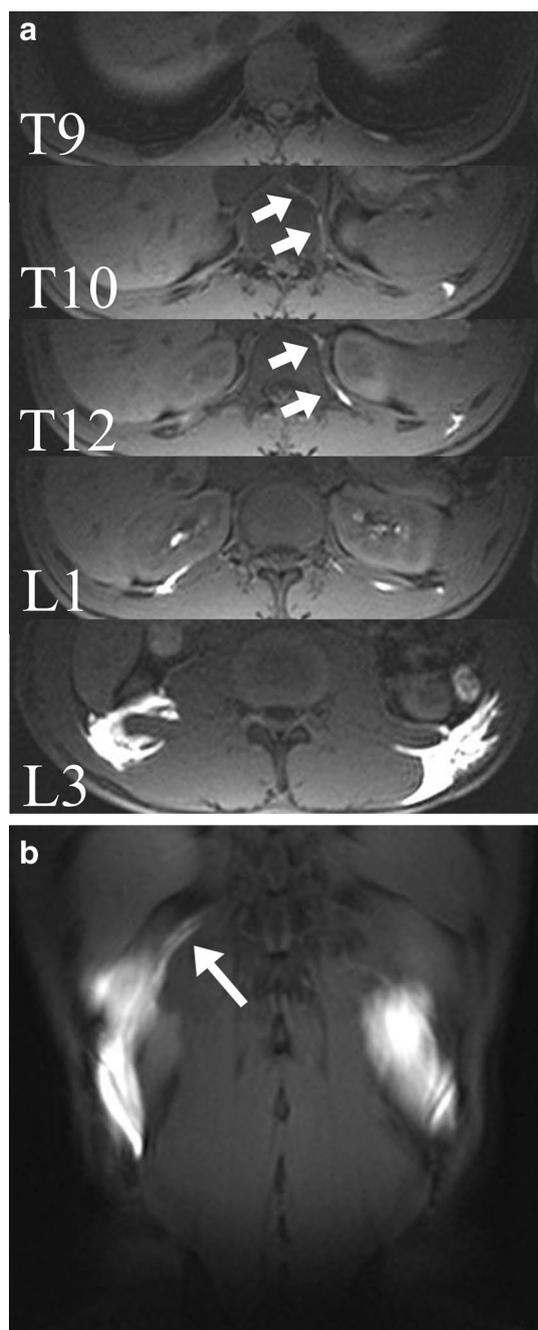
Magnetic resonance imaging (MRI) of local anesthetic (LA) spread into the paravertebral space (PVS) after QL B2 and QL Bi. a LA spread into the PVS was detected by MRI following QL B2 (white arrows). The volunteer imaged in this figure underwent left-sided QL B2 (right side of each image). In contrast, MRI did not show LA spread into the PVS following QL Bi. The volunteer in this image underwent right-sided QL Bi (left side of each image). Top image: Level of the T9 vertebral body. Second image from the top: Level of the T10 vertebral body. Third image from the top: Level of the T12 vertebral body. Second image from the bottom: Level of the L1 vertebral body. Bottom image: Level of the L3 vertebral body. All images are from the same volunteer. b Coronal section from a volunteer different from the one shown in Fig. 3a. LA spread into the PVS along the ribs after QL B2 administration (white arrow). The volunteer underwent right-sided QL B2 (left side of image). In contrast, QL Bi resulted in a maximum cranial spread that reached the T12 rib. The volunteer in this image underwent left-sided QL Bi (right side of image)
